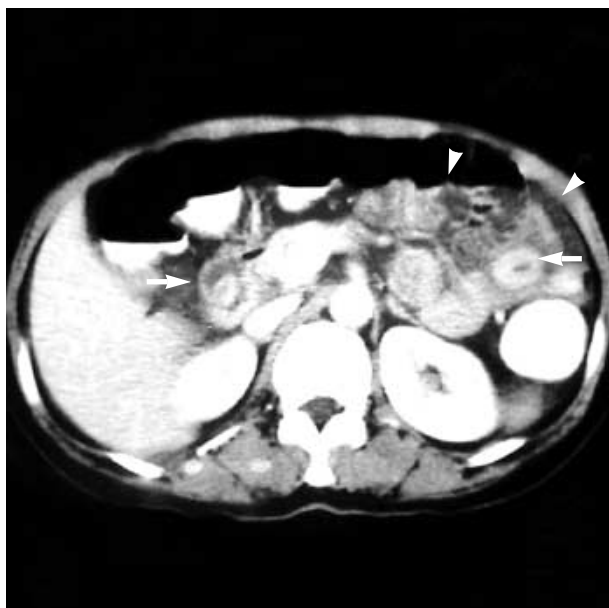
CT scan found thickened wall of the duodenum and ileum (arrows) and ascites (arrowheads).
